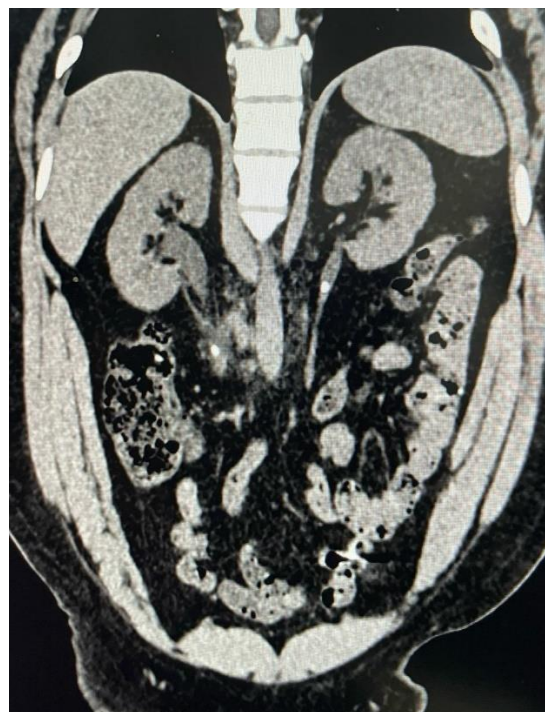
Coronal view of CT abdomen showing nonimpacted left ureteric stone with distal
